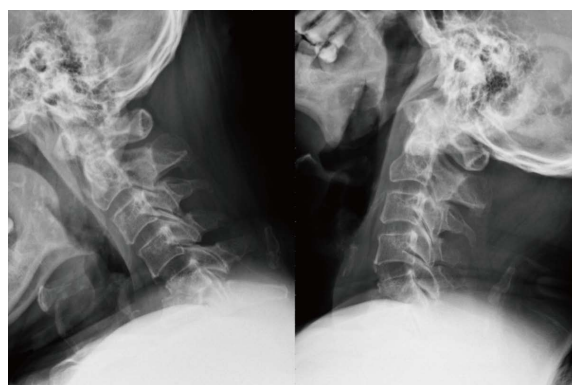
A 51-year-old man experienced intractable neck pain and neurologic deficit. Dynamic radiograph showed pathological fractures with kyphotic deformity of 5th and 6th cervical vertebrae.
